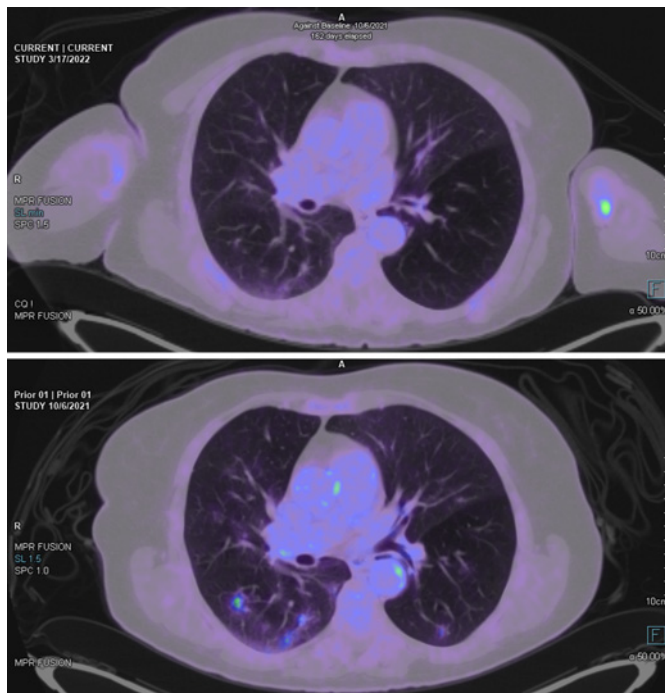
PET scan of the lung before (down) and after (up) treatment showed near complete resolution of multiple lung FDG-avid nodules.
